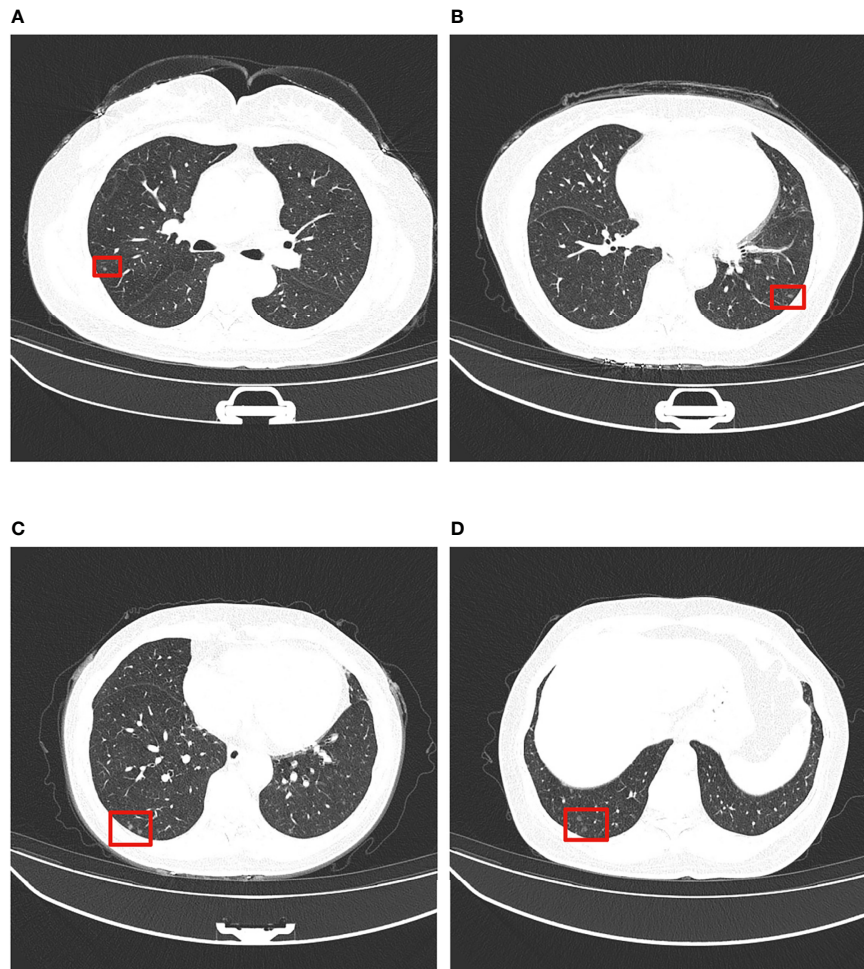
Typical thin-section CT presentation of MPMNs. Multiple ground glass density shadows in the middle and lower lobes of the left and right lungs (shown in red boxes), 0.2-0.4 cm in diameter, with irregular shadows and slightly blurred boundary. (A-D) show ground glass density nodules in left and right lungs at different CT sections.
